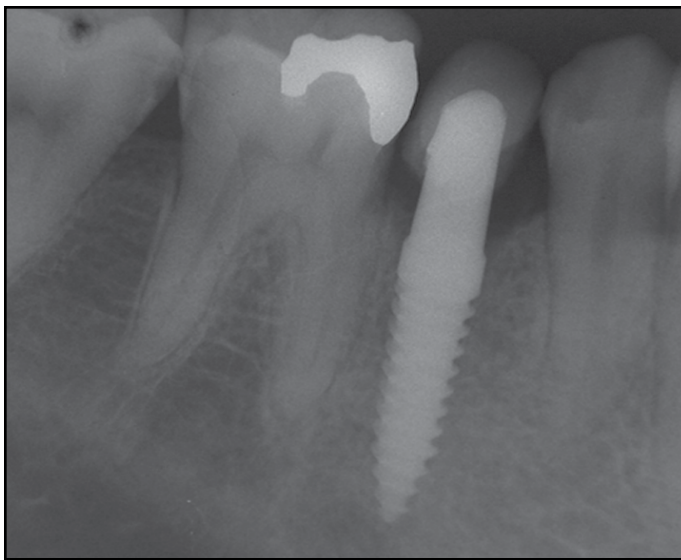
Immediate postoperative periapical radiograph.
